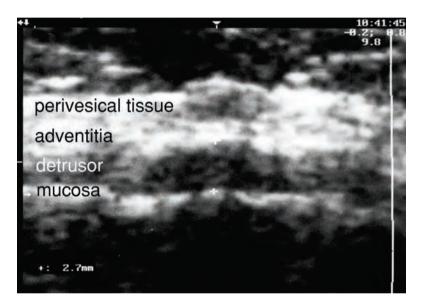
Ultrasound image of the anterior bladder wall in a patient with hyperechogenic (fatty) tissue around the bladder which makes measurements of bladder wall thickness but not detrusor wall thickness difficult. Enlargement factor of the ultrasound image 9.8fold.
